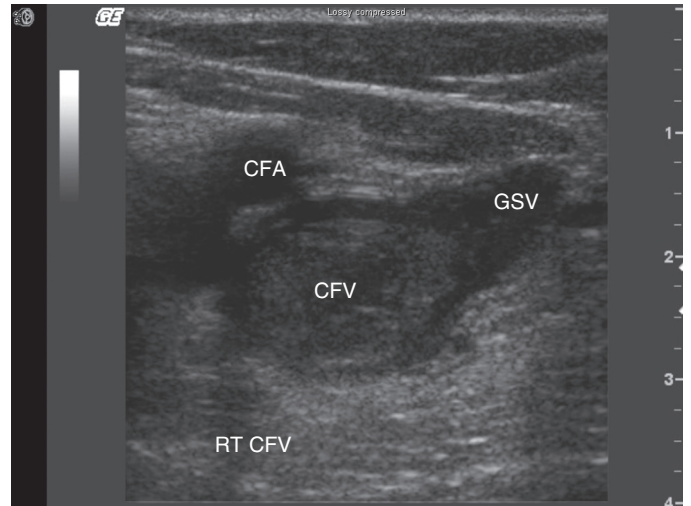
DVT involving the right common femoral vein (RT CFV) seen on venous ultrasound examination. The common femoral vein (CFV) does not compress and is dilated. Thrombotic material can be visualized within the vein. CFA = common femoral artery; GSV = greater saphenous vein. (Courtesy Gregory Piazza, MD, MS.)
